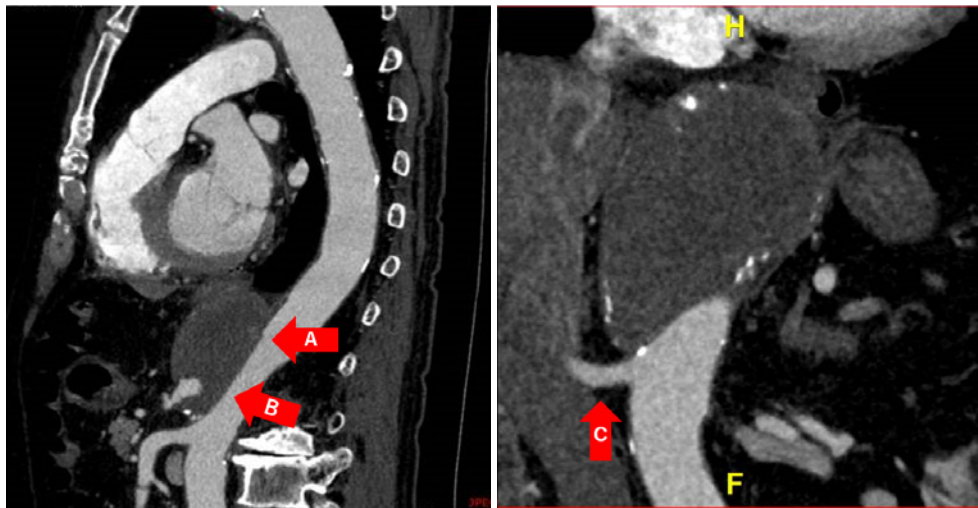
Preoperative CT scans
